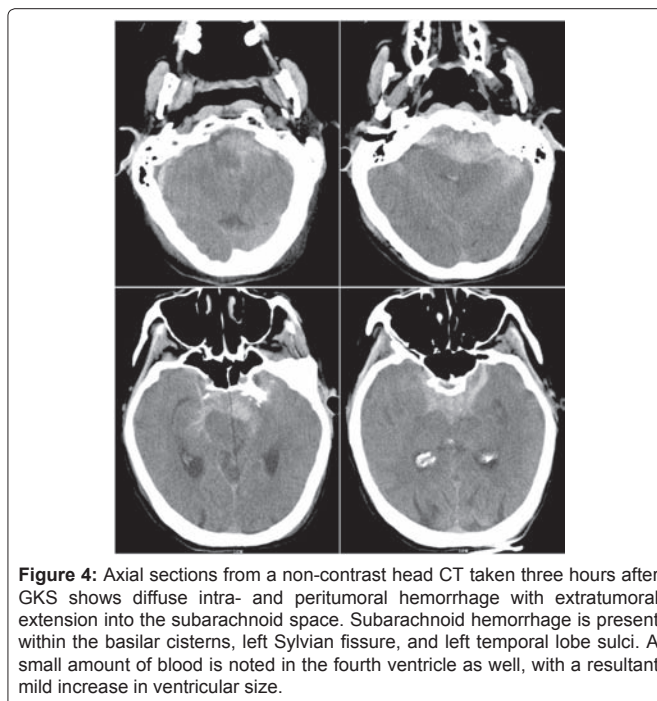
Axial sections from a non-contrast head CT taken three hours after GKS shows diffuse intra- and peritumoral hemorrhage with extratumoral extension into the subarachnoid space. Subarachnoid hemorrhage is present within the basilar cisterns, left Sylvian fissure, and left temporal lobe sulci. A small amount of blood is noted in the fourth ventricle as well, with a resultant mild increase in ventricular size.
